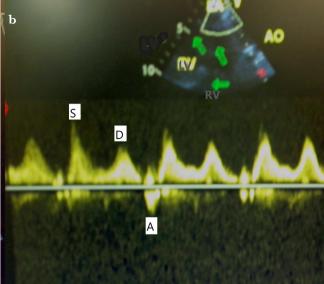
a, b. (a) Upper oesophageal ascending aorta long axis with colour Doppler showing good flow in right pulmonary artery (perioperative); (b) mid-oesophageal 2 chamber with pulsed wave Doppler across left upper pulmonary vein showing good intraoperative (left) pulmonary flow with normal patterns of 'S', 'D' and 'A' waves (S>D) S: systolic; D: diastolic; A: atrial reversal waves of pulmonary venous flow
